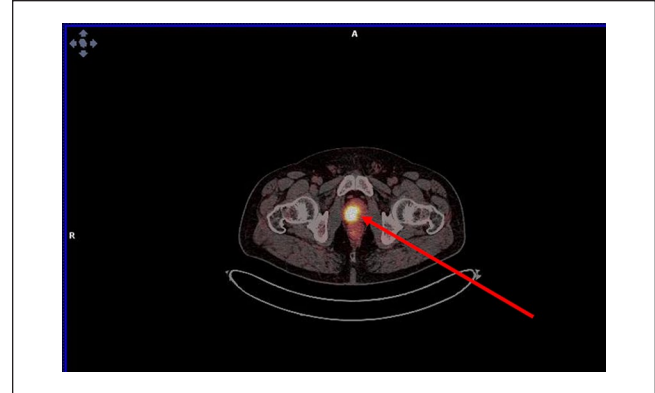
PSMA-PET showing increased uptake in the prostate (red arrow).
